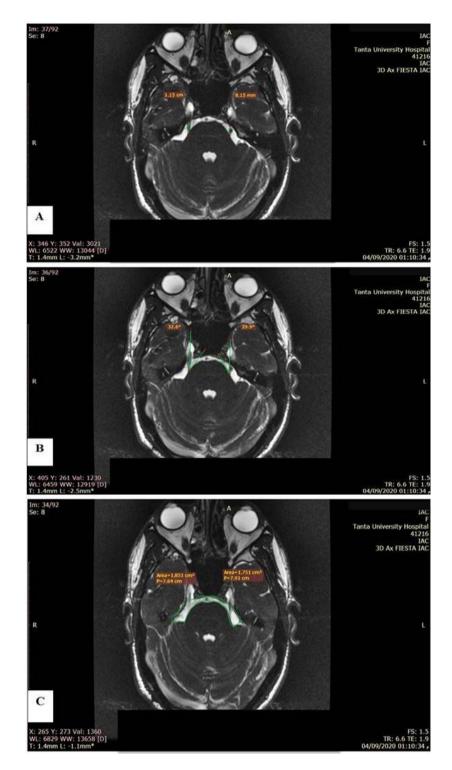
Male patient 49 years old, presented by left sided trigeminal neuralgia. MRI brain revealed: (A, B & C) Axial FIESTA images revealed length of cisternal part of trigeminal nerve, trigeminal pontine angle and cross sectional area of CPA cistern respectively. Length of cisternal part of right trigeminal nerve (10mm) & length of cisternal part of left trigeminal nerve (8.15mm). Right trigeminal pontine angle measures about 32.6° & left trigeminal pontine angle measures about 29.9°. Cross sectional area of right CPA cistern measures about 1.85 cm<sup>2</sup> and left cross sectional area of CPA cistern measures about 1.75cm<sup>2</sup>. All measures of the left side are less than those in right side. (Idiopathic case of left side trigeminal neuralgia) One of the most unpleasant types of facial discomfort is TN. It is characterised by transient electric shock-like pains that are localised to one or more trigeminal nerve divisions and are abrupt in their onset and termination. History and clinical examination can diagnose TN, but radiographic imaging analysis is required to detect any cerebral pathology [10].
